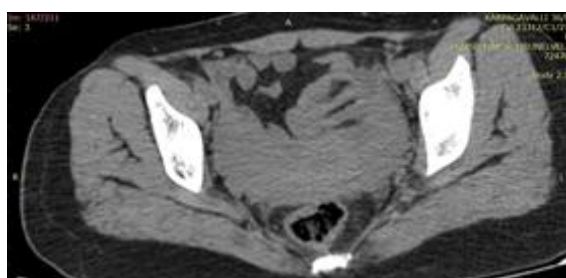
CT Abdomen showing telescoping of bowel inside another bowel possibility of intussusception
